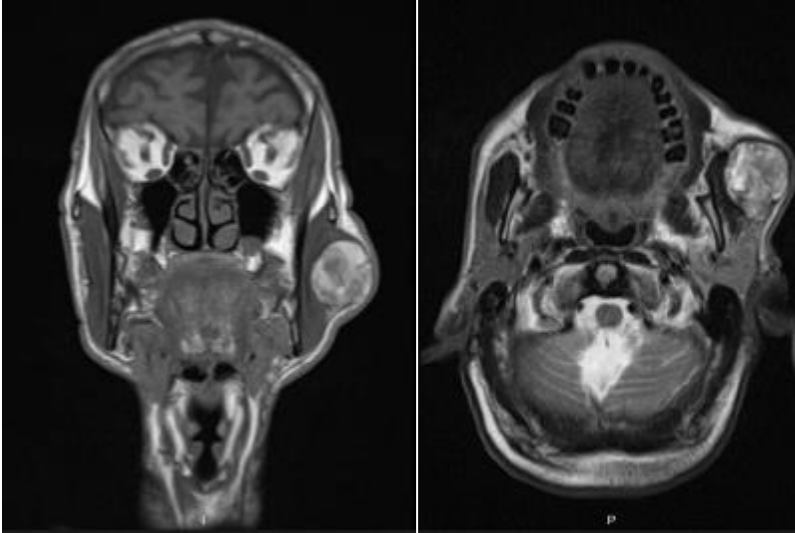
Contrast-enhanced neck-diffusion magnetic resonance imaging examination of the mass
